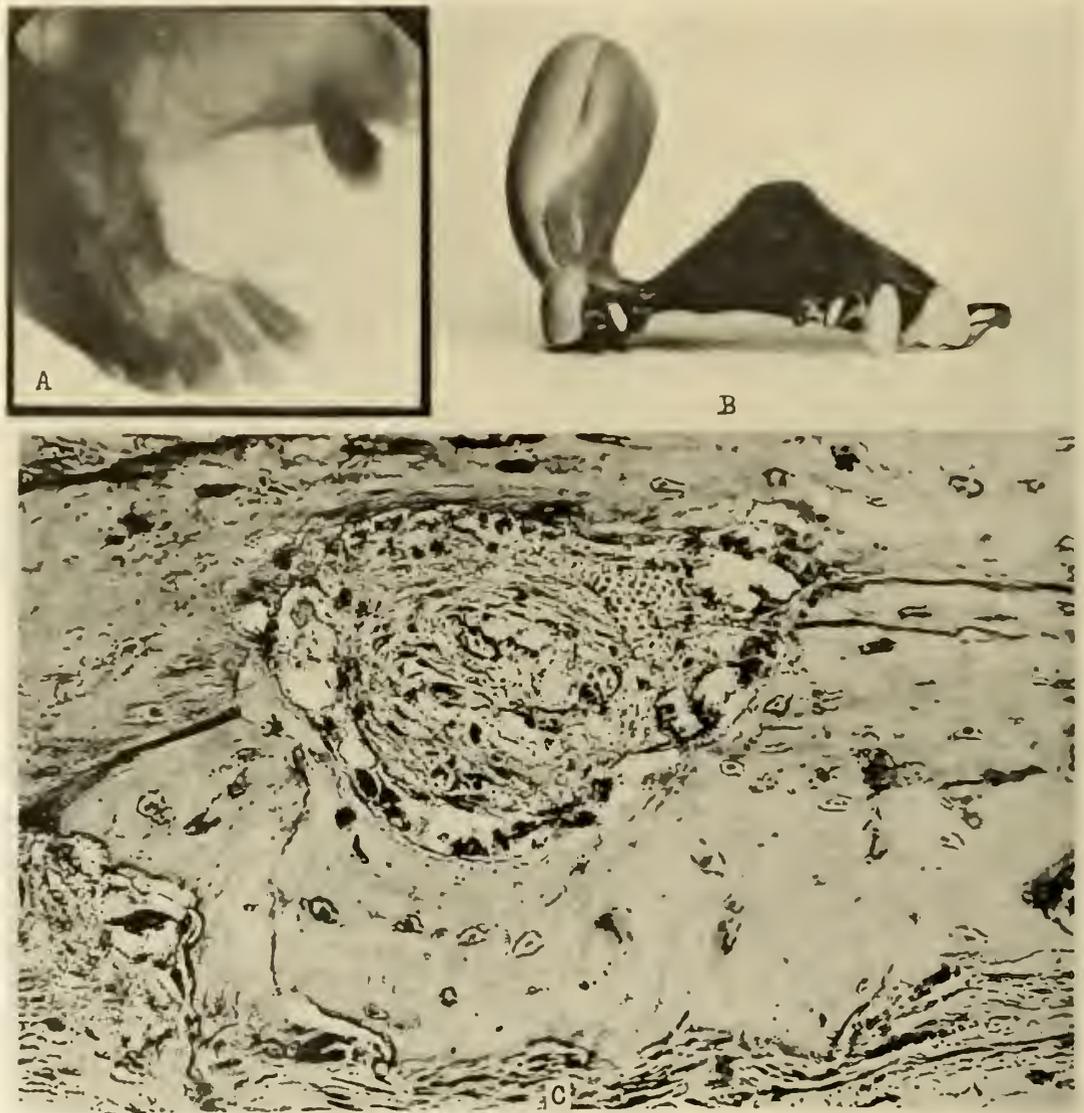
A, A ROENTGENOGRAPHIC VIEW; B, ARTIFICIAL DENTURE AND SPLINT TO SUPPORT THE DESTROYED CHEEK BONE AND PERMIT ORAL MUCOUS MEMBRANE TO EXTEND AND DISPLACE ALL CYST TISSUES. RESULTS EXCELLENT. C, SECTION OF BONE ADJOINING ADVANCING CYST. NOTE THE ACTIVE OSTEOCLASTIC PROCESS. CASE No. 1098.
